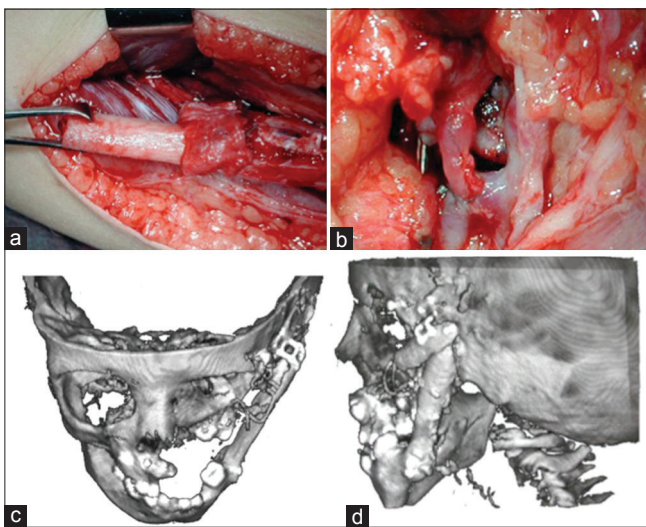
Pruzansky-Kaban Type III. Microvascular fibula transfer in a 10-year-old patient. (a) Harvesting of the fibula; (b) microvascular anastomosis; (c) three-dimensional (3D) computed tomography (CT) reconstruction after fibula transplantation to the left mandible; (d) 3D CT reconstruction, profile view
